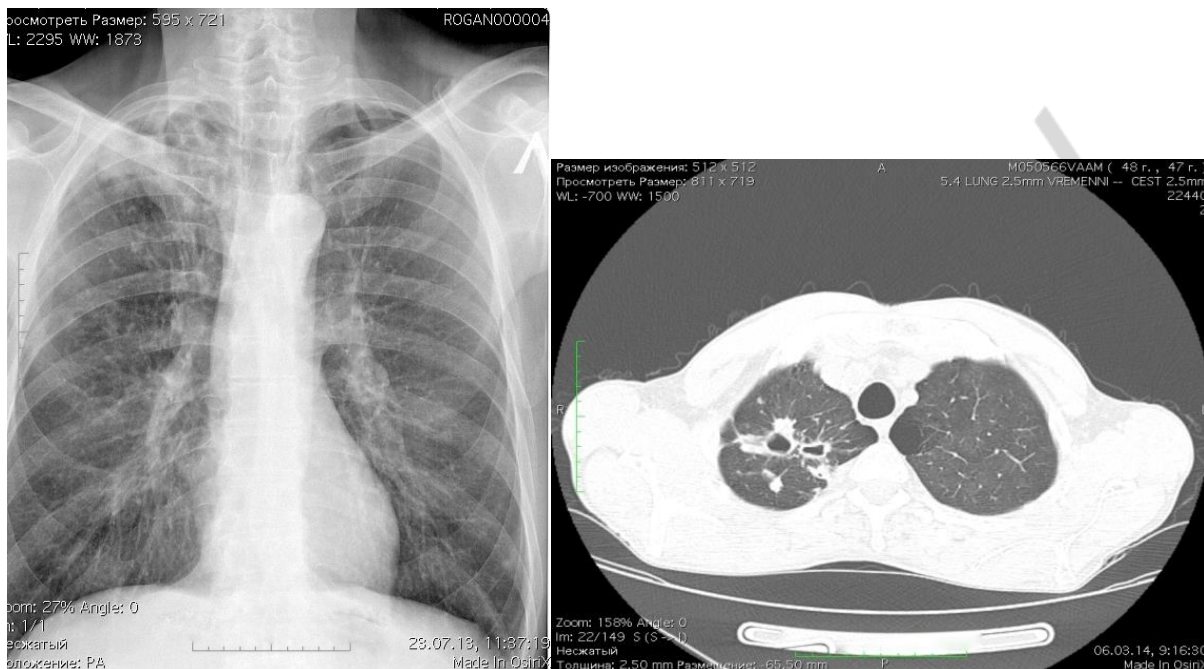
Survey X-ray and CT of patient M.
